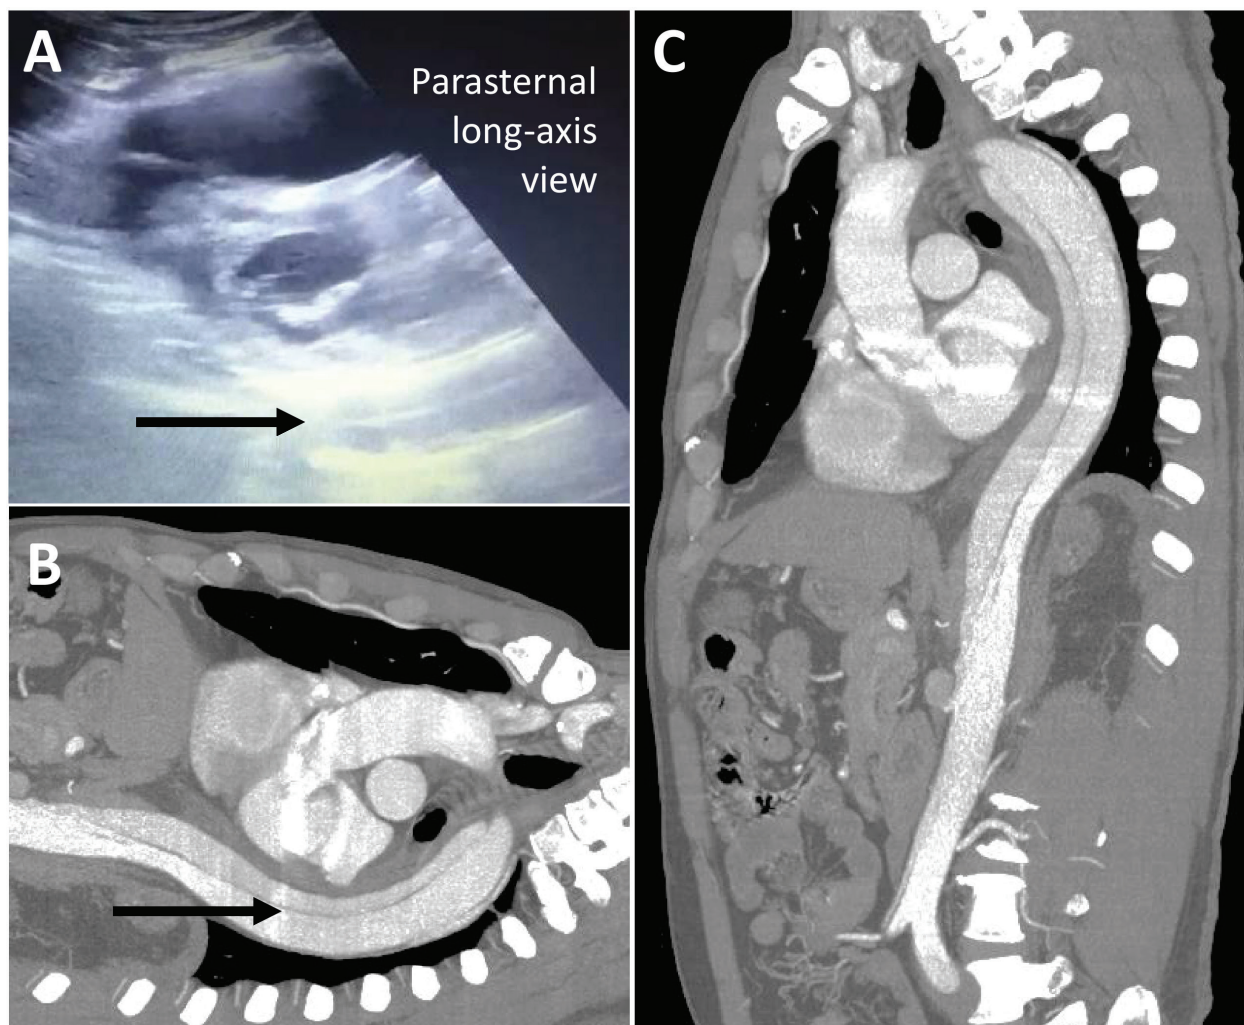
Transthoracic echocardiography (Panel A) and CT scans (Panels B and C).
